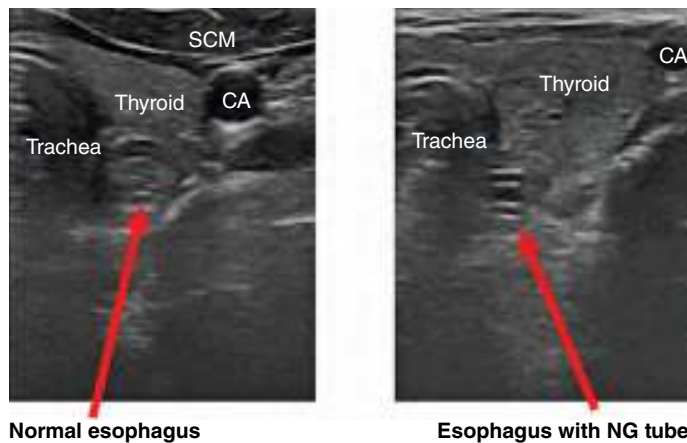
Ultrasound images of the esophagus without (left) and with (right) the NG tube. CA, carotid artery; SCM, sternocleidomastoid muscle. (Used with permission from reference 50.)
